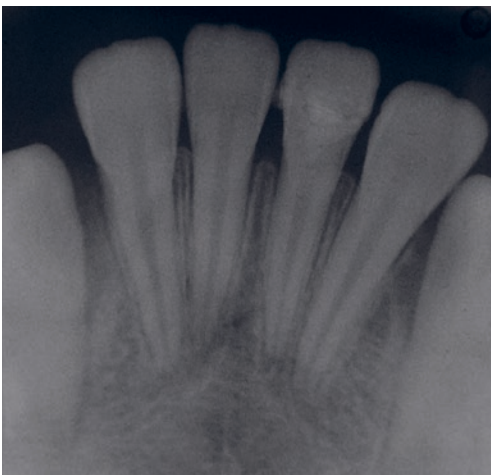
13 Months radiographic control.
